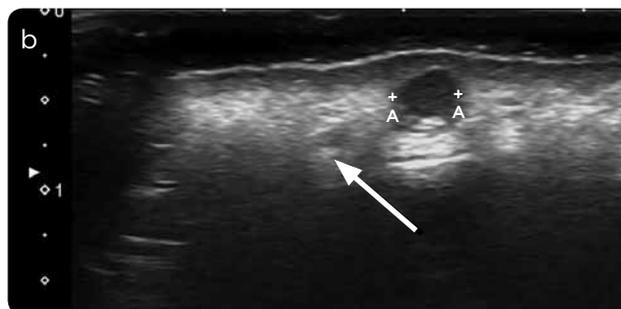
a) Clinical image of frontal region of patient consulting for nodule appearance. b) Ultrasound of frontal region showing two types of exogenous material: silicone in oil, with aspect in snowstorm (white arrow) and pseudocyst corresponding to hyaluronic acid (marks +A).
